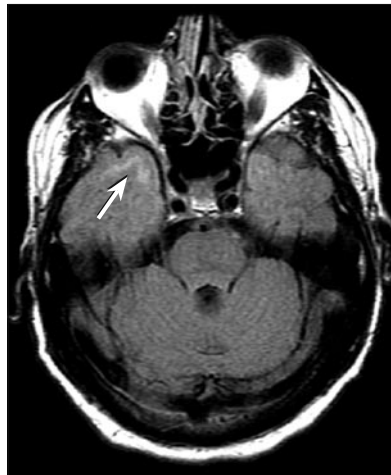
Axial FLAIR MR image demonstrates right temporopolar subcortical white matter hyperintensity (arrow), which is characteristic of CADASIL.
